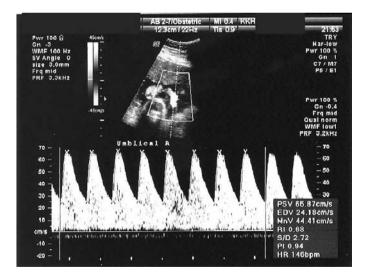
Umbilical artery doppler study.
